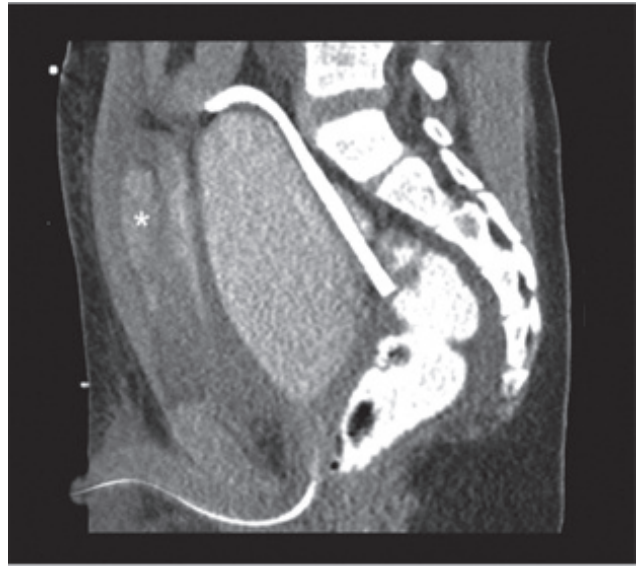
CT cystogram demonstrating an extraperitoneal bladder perforation (*) due to trocar injury during laparoscopic appendectomy. A urethral catheter and an intraperitoneal Jackson-Pratt drain can be seen. The injury was managed with an indwelling urethral catheter for 7 days. A voiding cystourethrogram at the time of catheter removal demonstrated no leakage of urine and a normal-appearing bladder and urethra.
